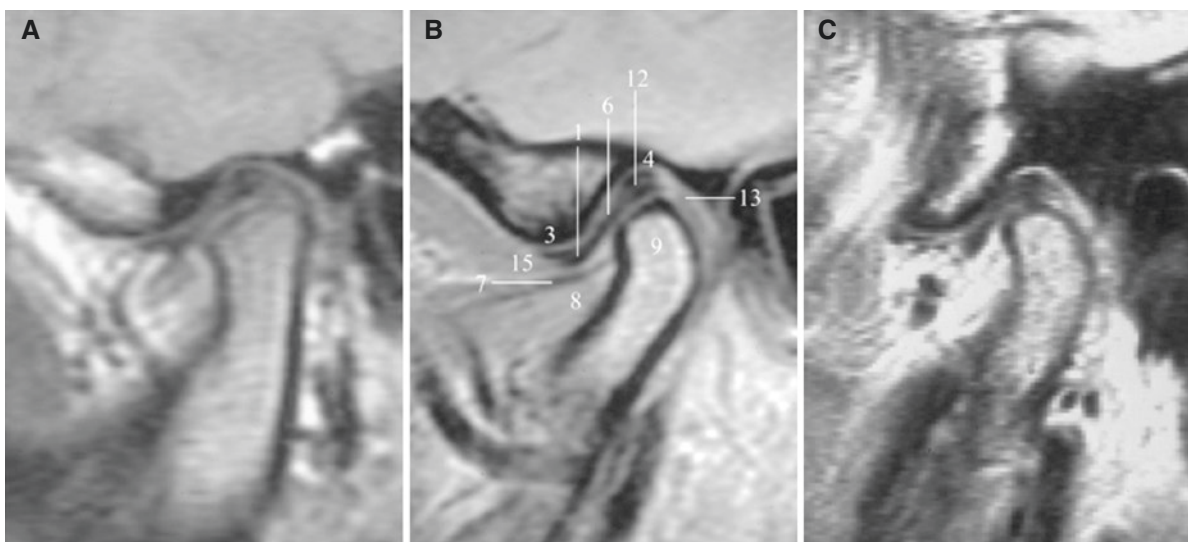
Normal bone and disc anatomy, asymptomatic volunteers; oblique sagittal MRI. (A) 9-year-old, (B) 40-year-old, (C) 56-year-old (C reproduced with permission from Larheim et al. 2001a)
